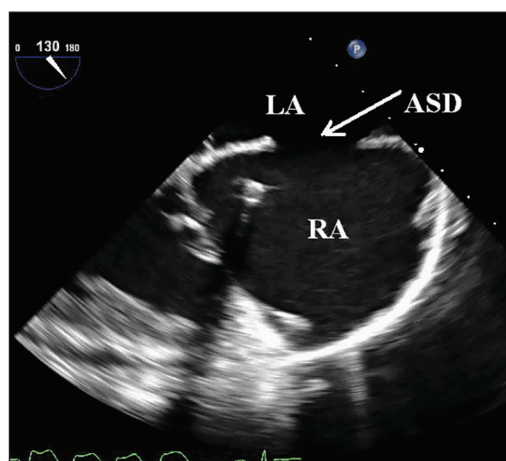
Transesophageal echocardiography two-dimensional mid esophageal modified bicaval view showing atrial septal defect with adequate rim. RA: Right atrium; LA: Left atrium
